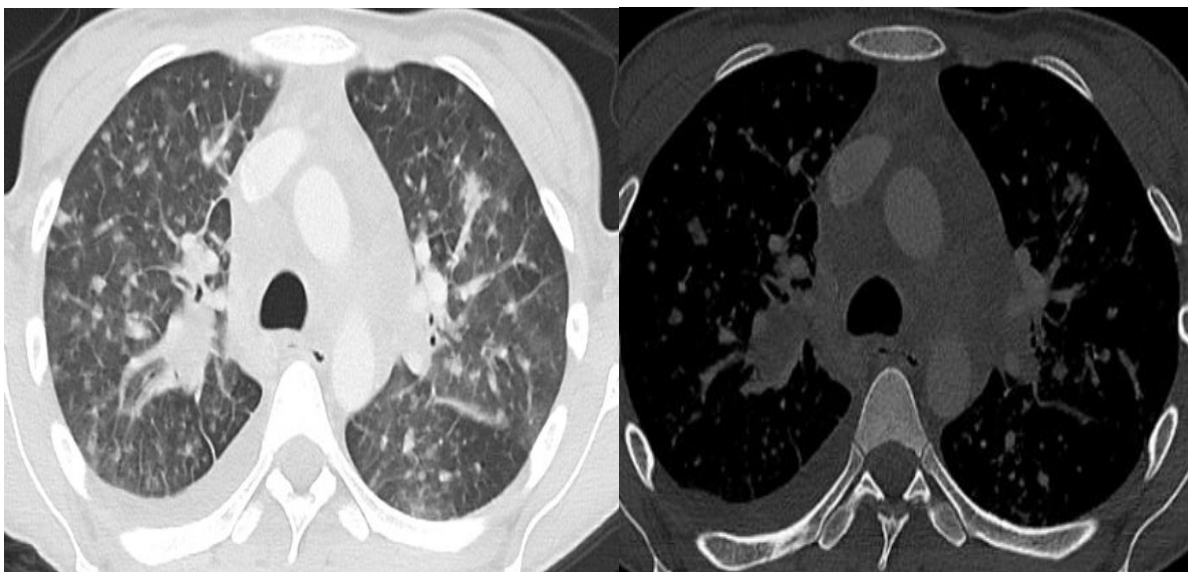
Axial chest CT scan showing multiple diffuse, bilateral parenchymal micronodules suggestive of miliary tuberculosis associated with a small pleural effusion on the right.
